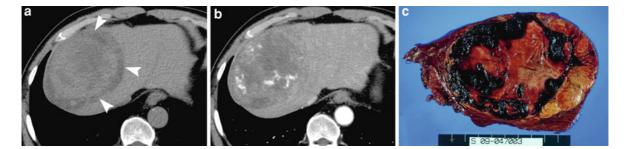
HCC with intratumoral hemorrhage. a Precontrast CT scan demonstrates a large tumor with internal hemorrhage, which resulted in hyperattenuation in the *central portion* of the main tumor with hypoattenuation (*arrowheads*). b Arterial
